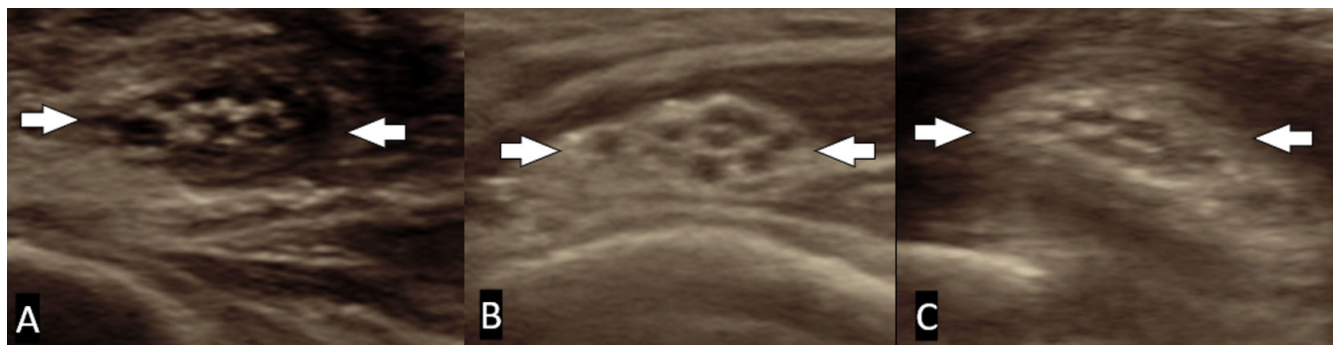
63-year-old male with ulnar neuropathy treated with subcutaneous transposition. Short-axis ultrasound images demonstrate the ulnar nerve (white arrows) at the time of injection (A), at 2-month follow-up (B), and at 6-month post-injection. Hypochoic enlargement and mild distortion of fascicles are present at all time points
